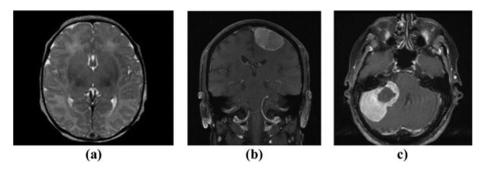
A computer-generated MRI image has been provided [139]. Reprinted by permission from Elsevier.
